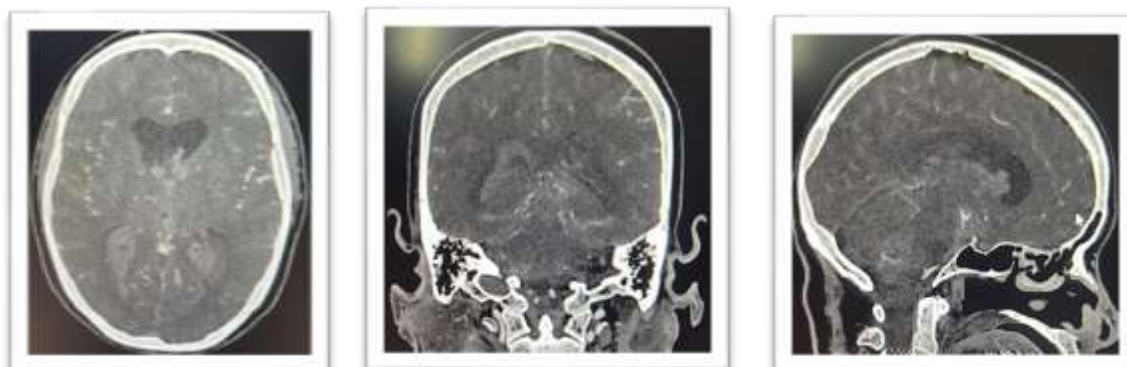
Computed Tomography Images-Axial, Coronal and sagittal
